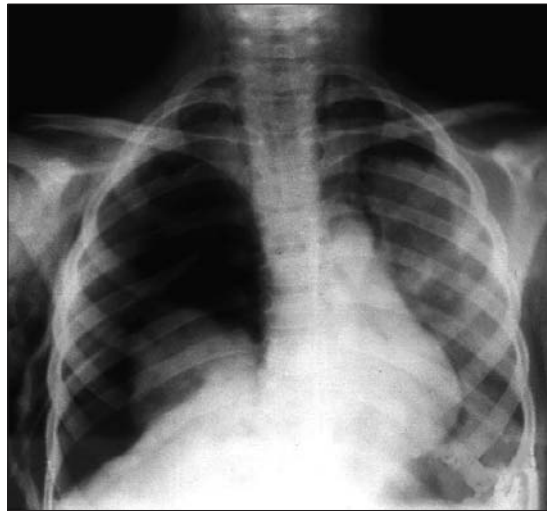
Chest radiograph obtained six hours after the initial presentation. Bilateral pneumothorax, more prominent on the right, is seen. Pneumomediastinum and soft tissue emphysema are observed. Right lung is seen to be collapsed below the hilus (fallen lung sign). A thorax tube has been inserted on the right.
